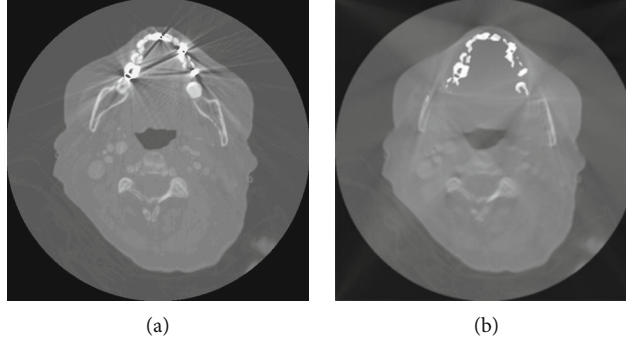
Original CT image and corrected CT image.
